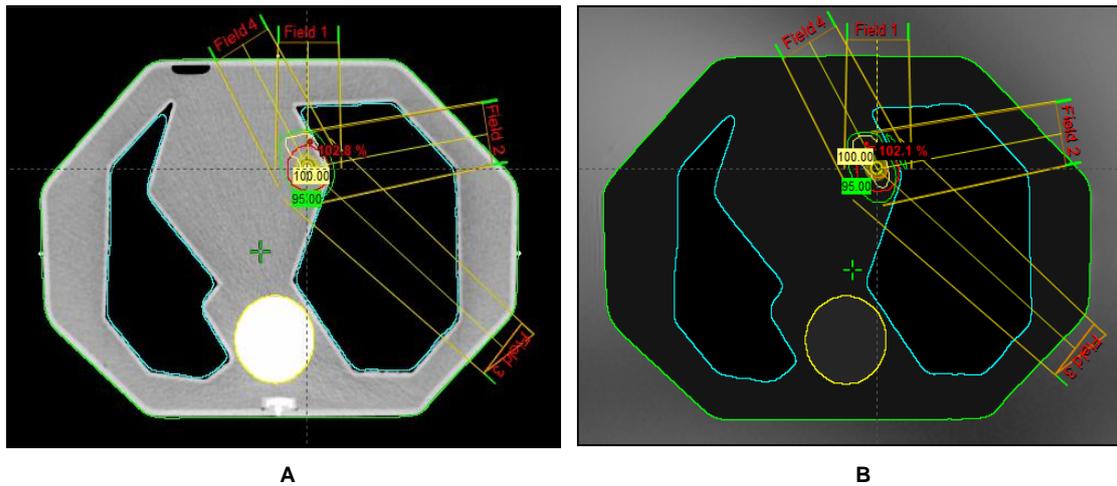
Comparison of Isodose distributions between: A-CT based plan and B-MRI based plan (wba).
